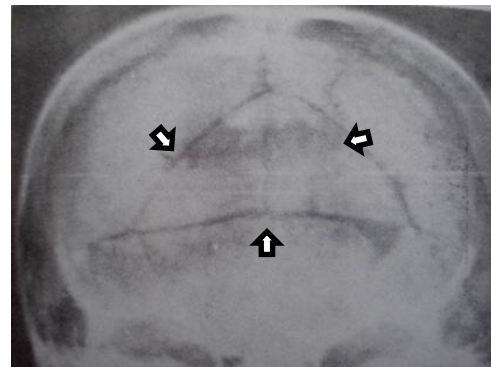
AP skull X-ray depressed skull fracture
